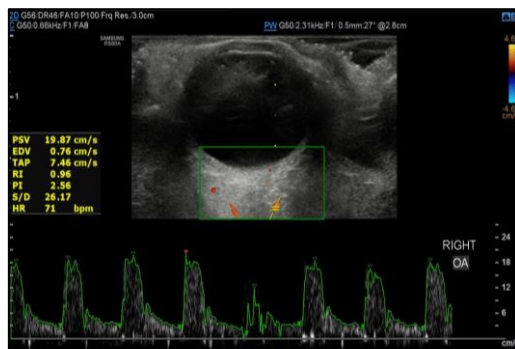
Colour Doppler Imaging: Ophthalmic Artery
